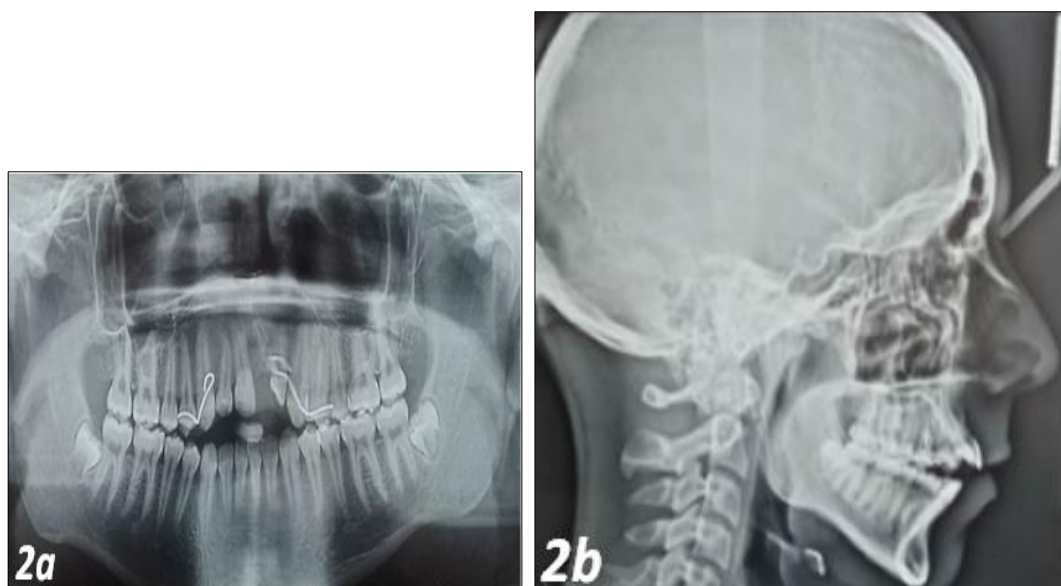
(a-b): Pre-treatment radiographs
